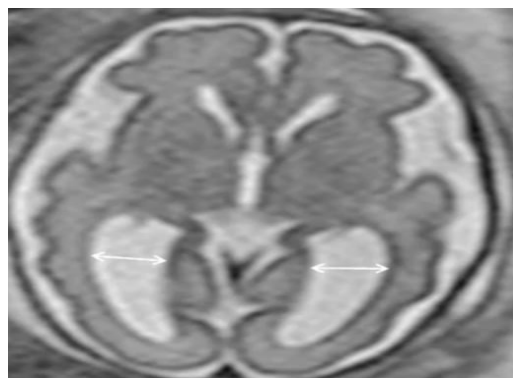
Axial T2 weighted MRI of 23 weeks fetus with bilateral mild ventriculomegaly
